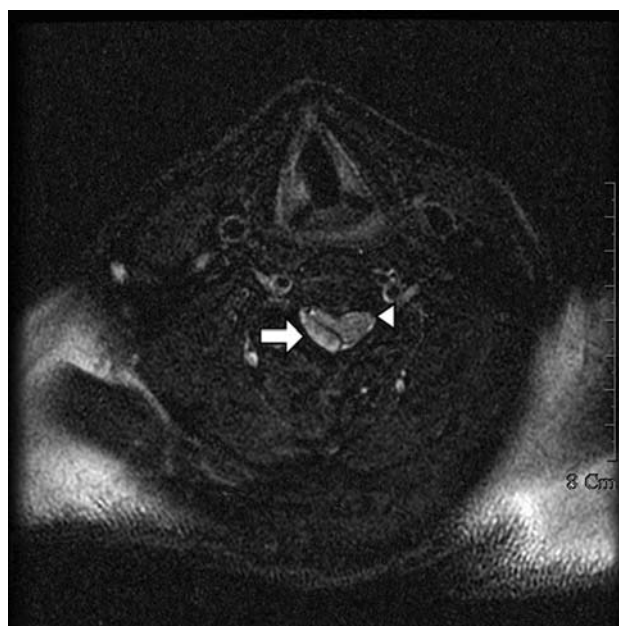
Axial T2-weighted cervical magnetic resonance image shows an ovoid epidural hematoma (arrow) in the right postero-lateral aspect and spinal cord compression (arrowhead)
